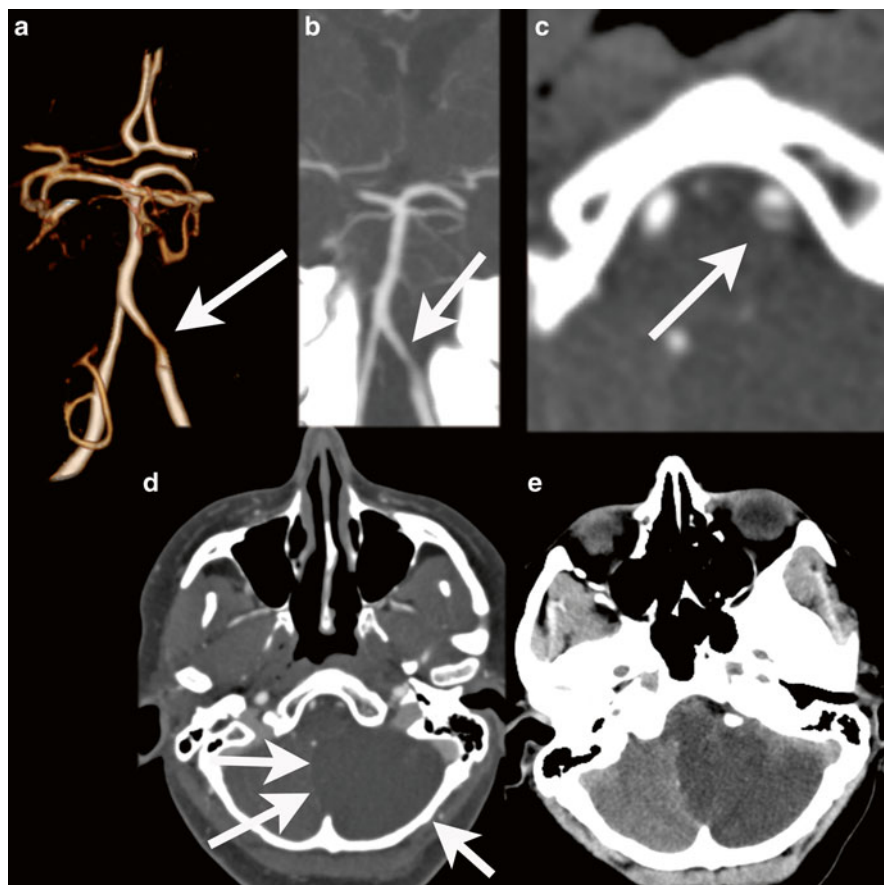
Vertebral artery dissection with PICA infarction. A 49 y/o female presented with dizziness, neck pain, nystagmus, and ataxia of the left arm. Initial NECT was normal. CTA demonstrates a tapering of the distal segment of the left vertebral artery, with a double-lumen sign on the CTA source images. A large infarction of the PICA territory in the left cerebellar hemisphere with mass effect was noted 2 days after the onset of symptoms. DE-CTA was performed at day 2. Bone-removed VR shows tapering of the distal segment of the left vertebral artery (a), also visible on the MIP reconstructions (b). Detailed images of the vertebral artery (c) Images at at 80 kVp demonstrates clearly the true and false lumen of the dissected left vertebral artery. At 120 kVp images this is also seen to a lesser extent, the mass effect of the cerebellar infarction is already noted at the CTA (d), but better seen at NECT at follow-up at day 3 (e)
